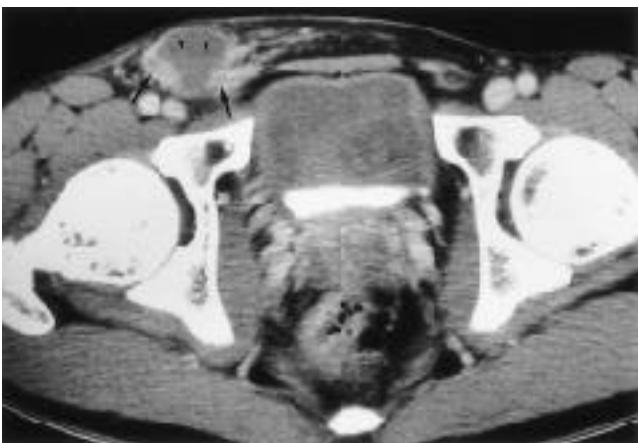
Contrast enhanced pelvic CT demonstrates an ovoid mainly cystic mass with a fluid-fluid level (arrowheads) and enhancing wall and solid portions (arrows) in the right inguinal area. Pathologically this mass was confirmed as a metastatic inguinal lymph node.
